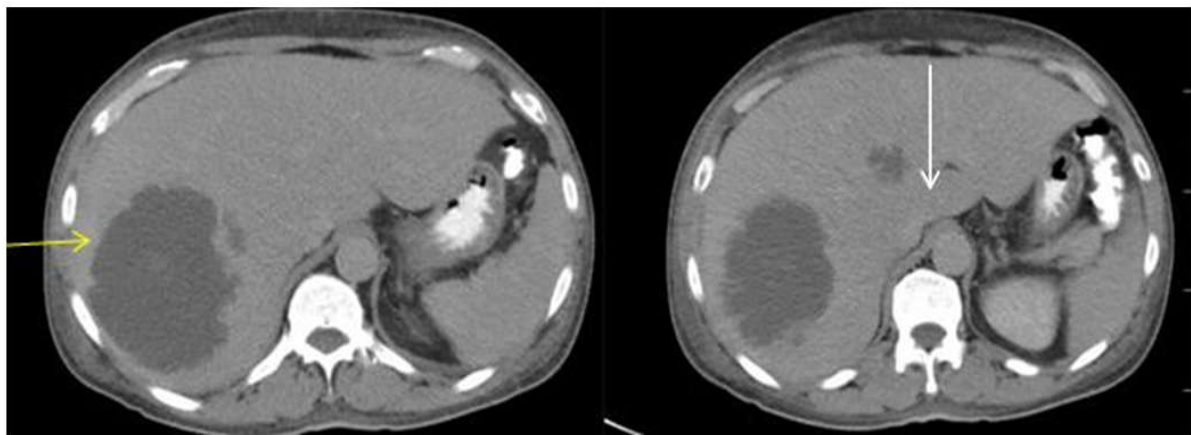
CT Abdomen (Arterial phase) Regional attenuation difference is noted in left lobe adjacent to left hepatic lobe abscess (white arrow) with a subtle increase in density (THAD). Large ill-defined perifocal hypodense area (yellow arrow) is noted adjacent to right hepatic lobe abscess (Target sign)
